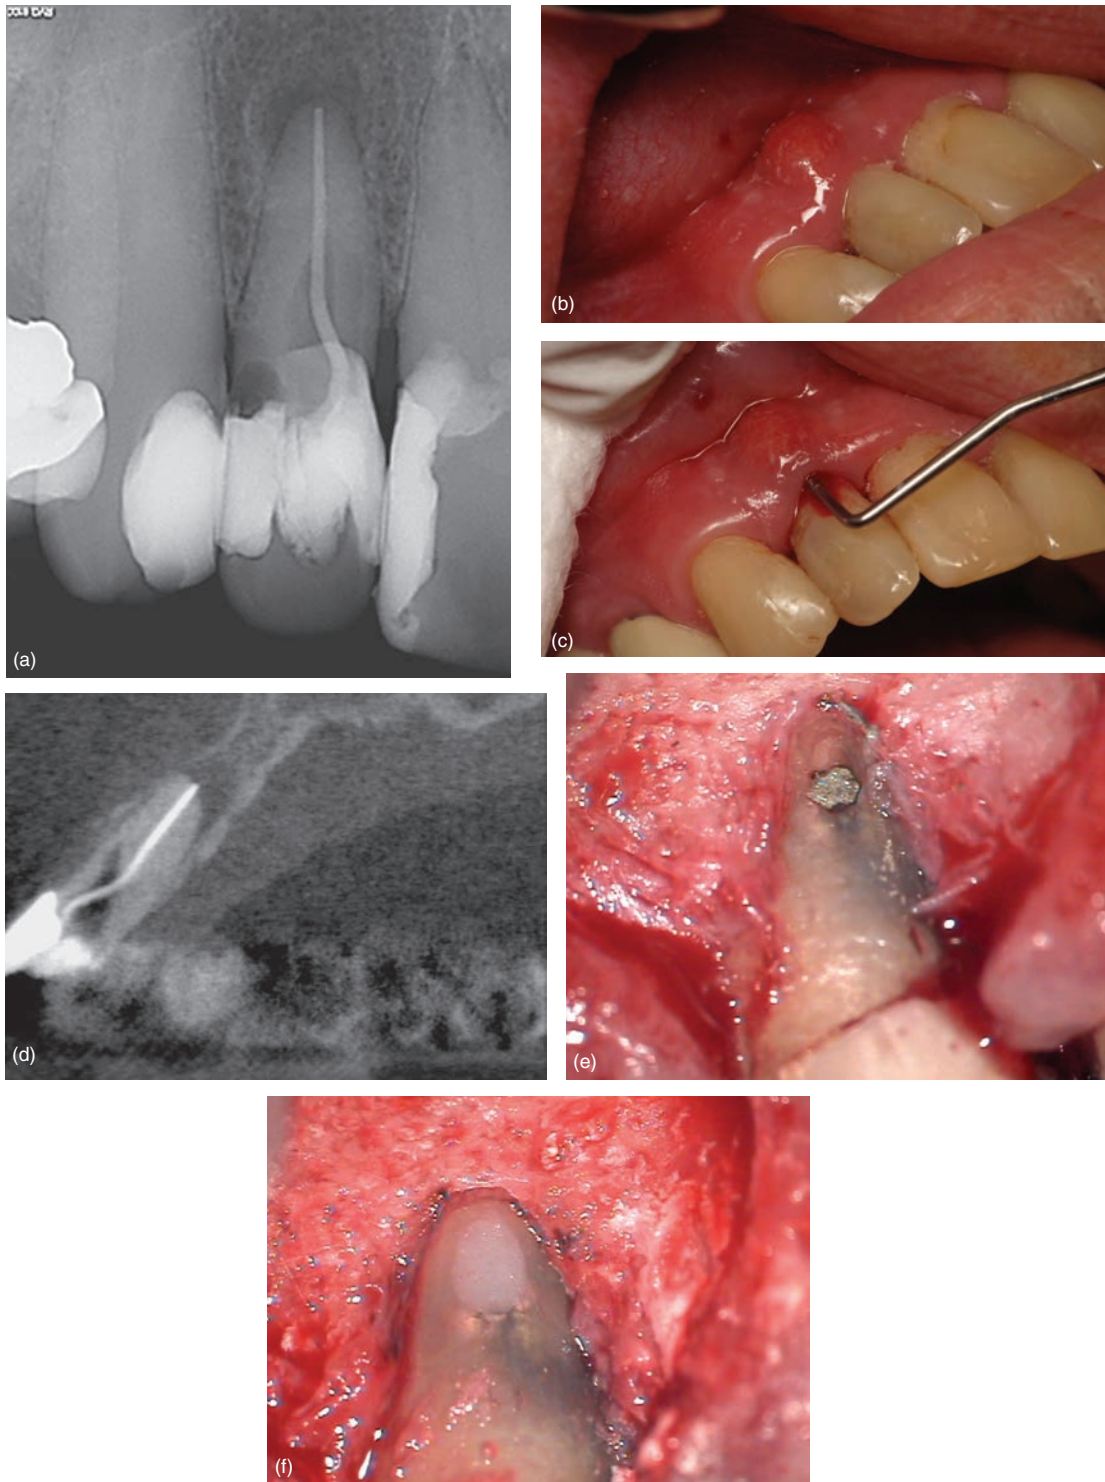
Buccal perforation at subgingival level maxillary right lateral. Patient was referred 24 hours following endodontic treatment. Prior to microsurgical treatment, non-surgical retreatment involved removal of gutta percha, disinfection, intracanal medicament, obturating apical portion of canal with gutta percha, and intracanal placement of MTA into the perforation site. Then surgical exposure of the perforation site and repair using Geristore. The rapid healing following surgical perforation repair clearly demonstrates the importance of immediate surgical intervention in such cases. (a) Preoperative radiograph; (b) preoperative photo of buccal swelling; (c) preoperative probing caused by the root perforation; (d) CBCT slice showing extent of buccal perforation; (e) surgical exposure of MTA at the perforation site; (f) perforation repaired with Geristore.
